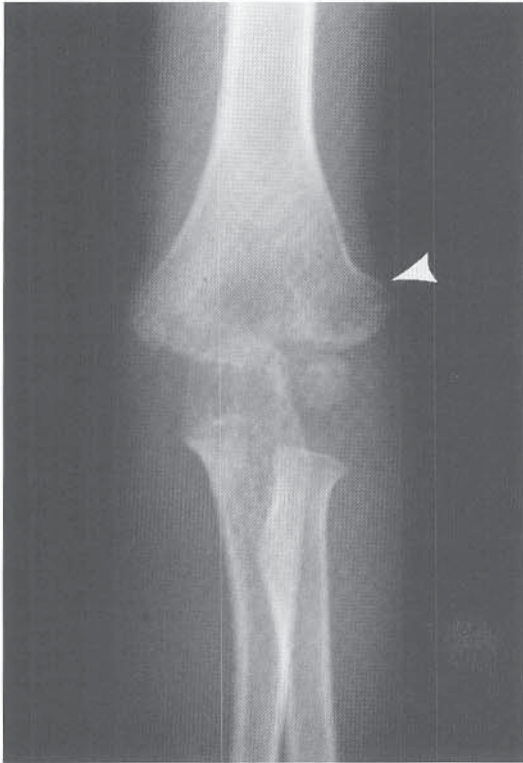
AP radiograph demonstrating lateral spur formation (*arrowhead*) following operative treatment of a displaced lateral condyle fracture. The prominent lateral spur creates the clinical appearance of mild cubitus varus.
